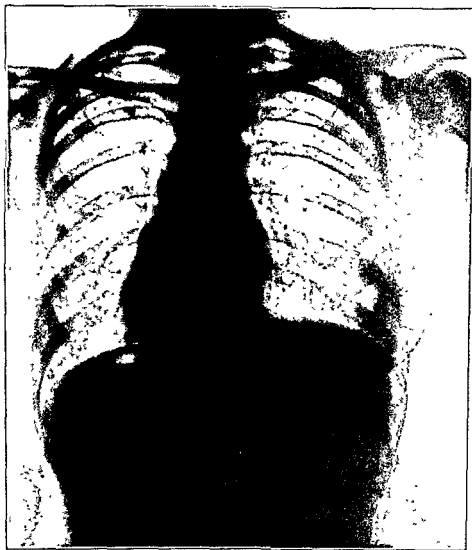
An x-ray of Case No. 2 taken 41 days later in which there is a rapid disappearance of the shadows present in Fig. 23.
